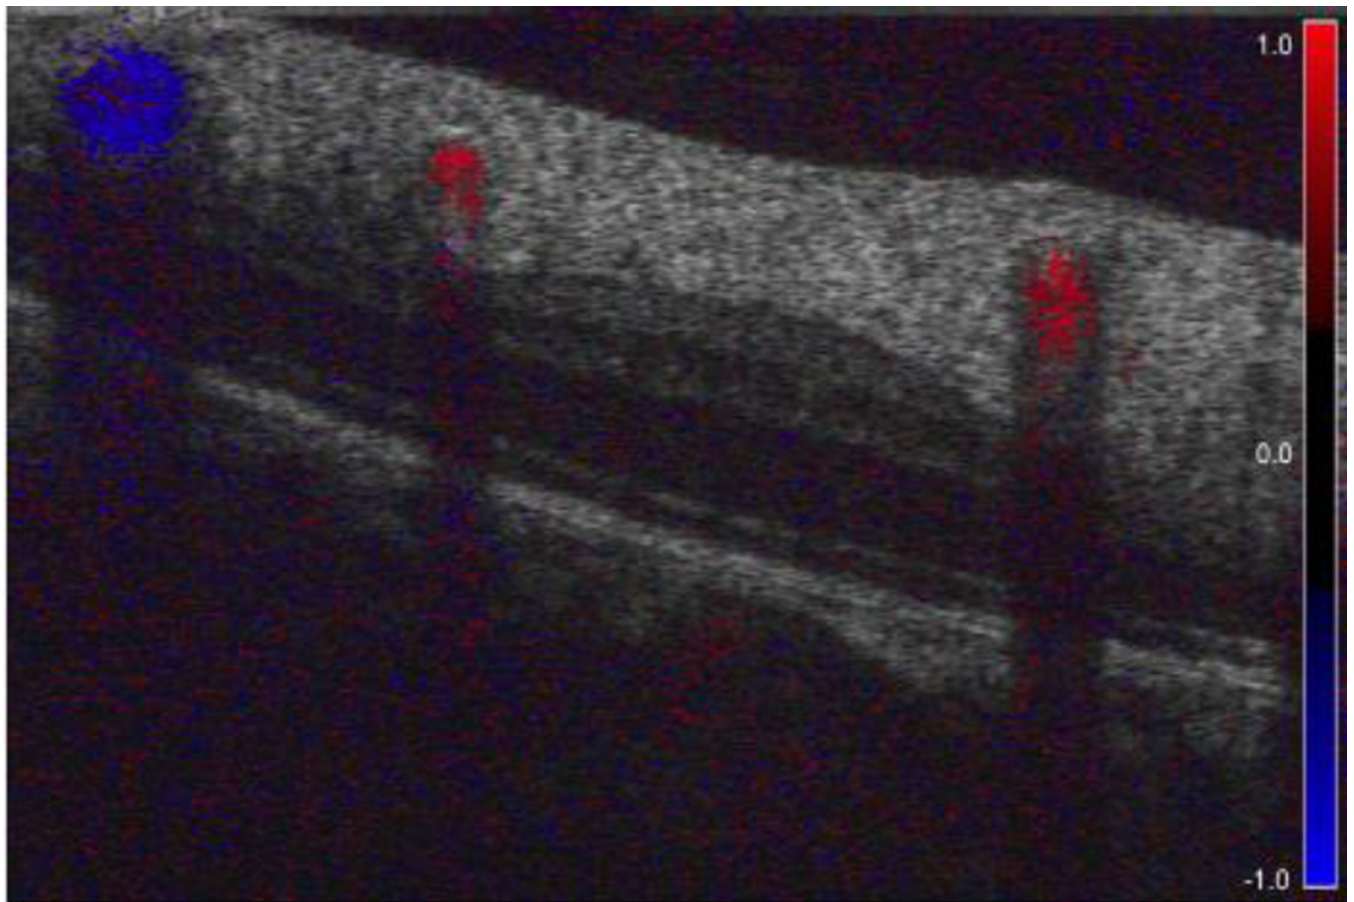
Doppler OCT cross-section of the retina. The lumen of retinal vessels is filled with color that corresponds with the direction and velocity of blood flow. Blockage of the light beam results in vertically elongated shadows underneath the vessels.
